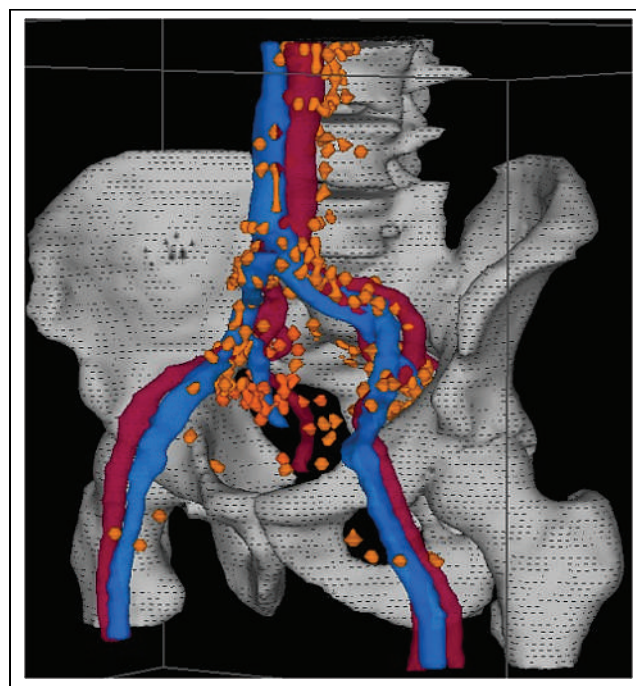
CT scan dataset showing veins (blue), arteries (red), bones (gray) and all PSMA-positive LNs of patients with PSA persistence (orange).
